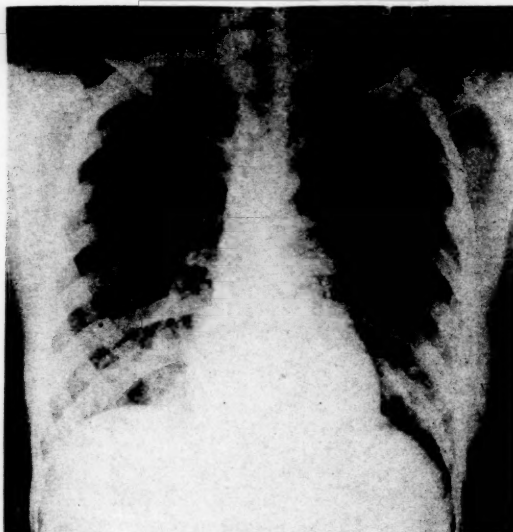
Roentgenogram of the patient's chest in Case VII.
